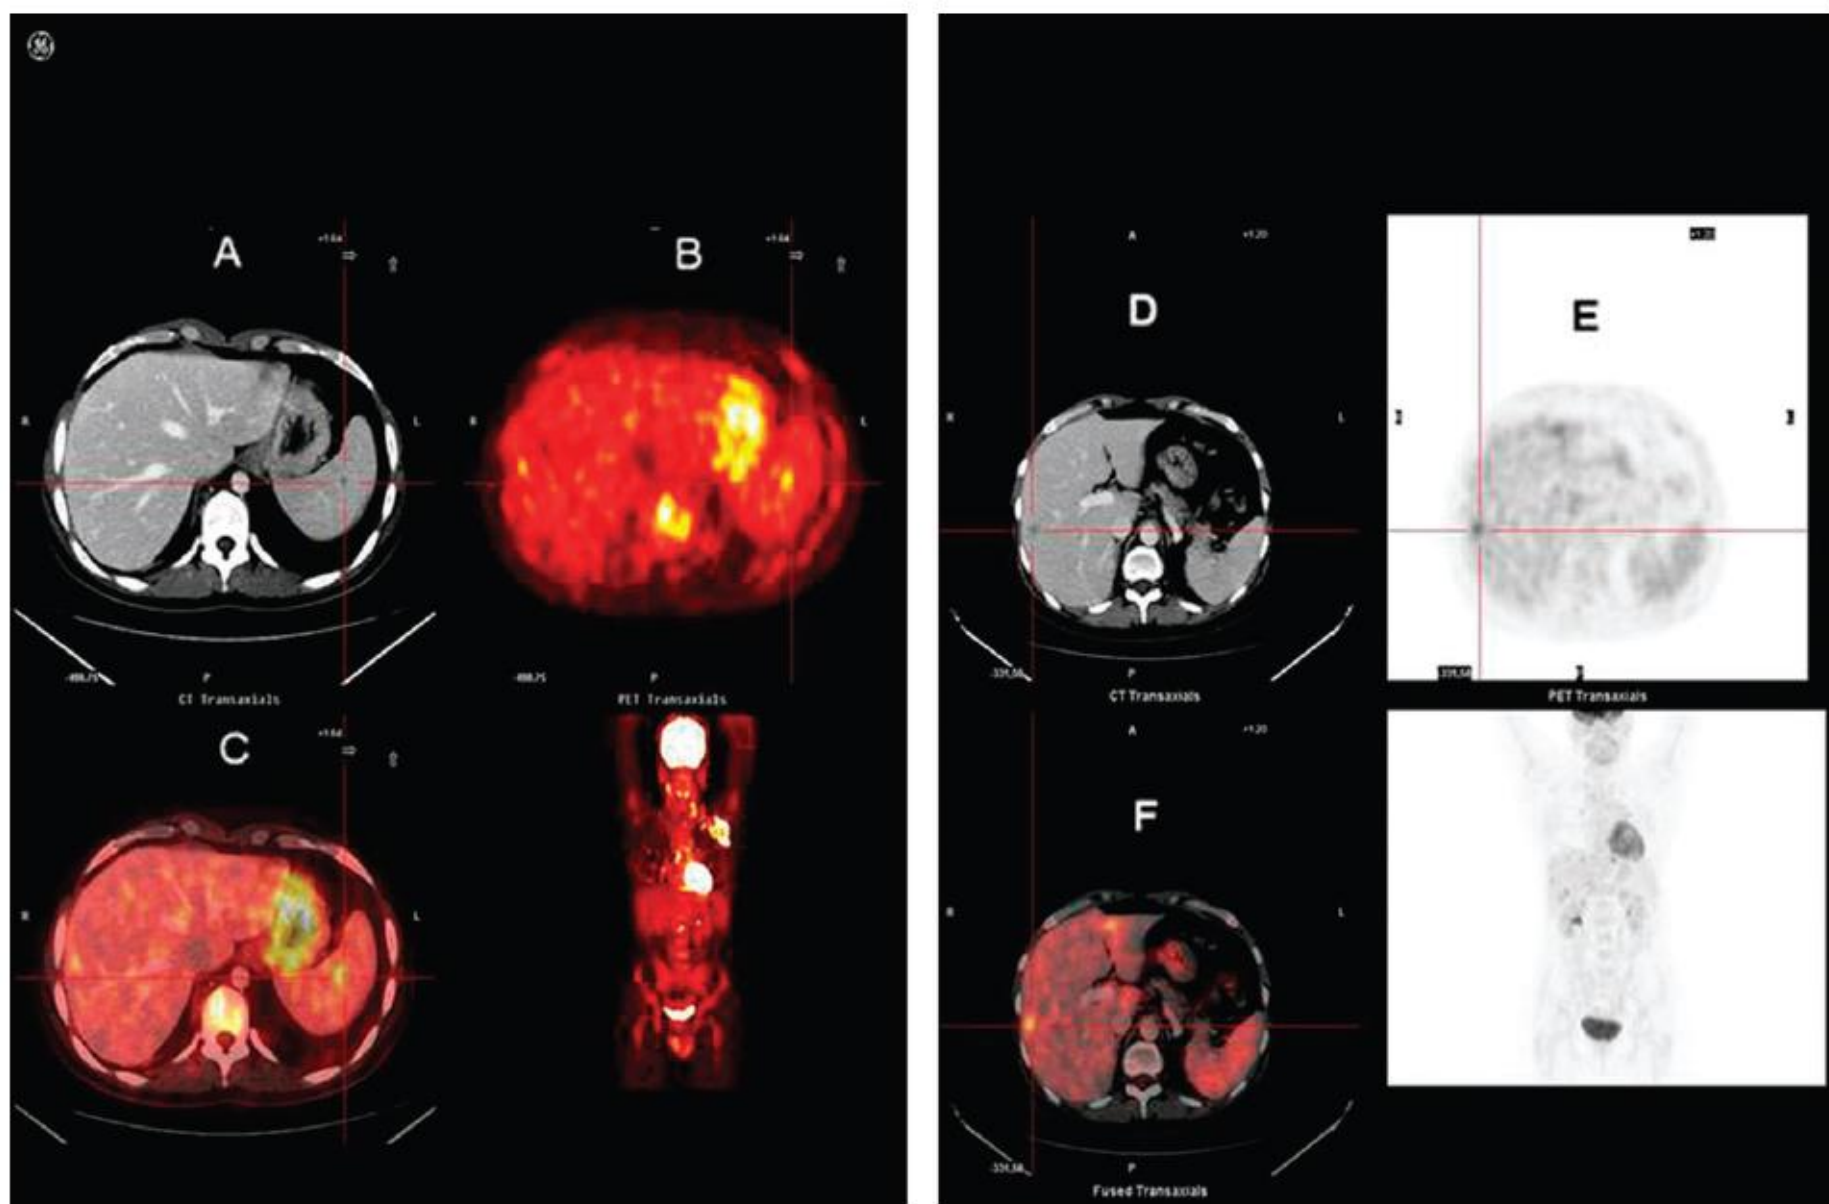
Splenic lymphoma nodule, as revealed by fused PET/contrast-enhanced CT: (A) a subcentimeter nodular hypodensity in respect to the surrounding tissue during the portal phase of perfusion study at CT, (B) FDG focal uptake at PET scans, and (C) imaging of fusion of the nodule. Liver lymphoma nodule, as revealed by fused PET/contrast-enhanced CT: (D) a centimeter nodular hypodensity in respect to the surrounding tissue during the portal phase of perfusion study at CT, (E) FDG focal uptake at PET scans, and (F) imaging of fusion of the nodule. CT, computed tomography; FDG–PET, 2-[fluorine-18]fluoro-2-deoxy-D-glucose–positron emission tomography.
